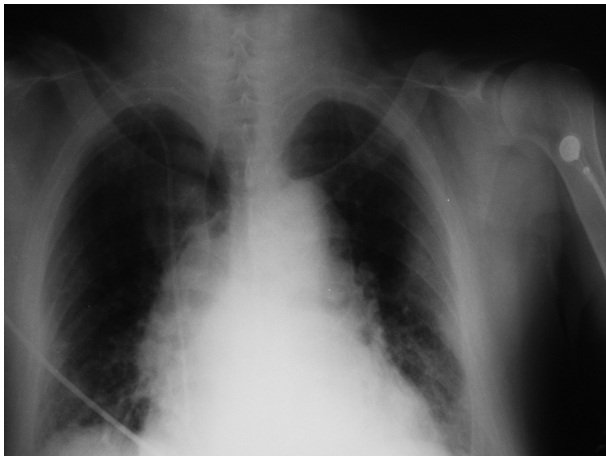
Chest X-ray (decubitus). Non-assessable cardiomegaly, Discrete mediastinal widening.
